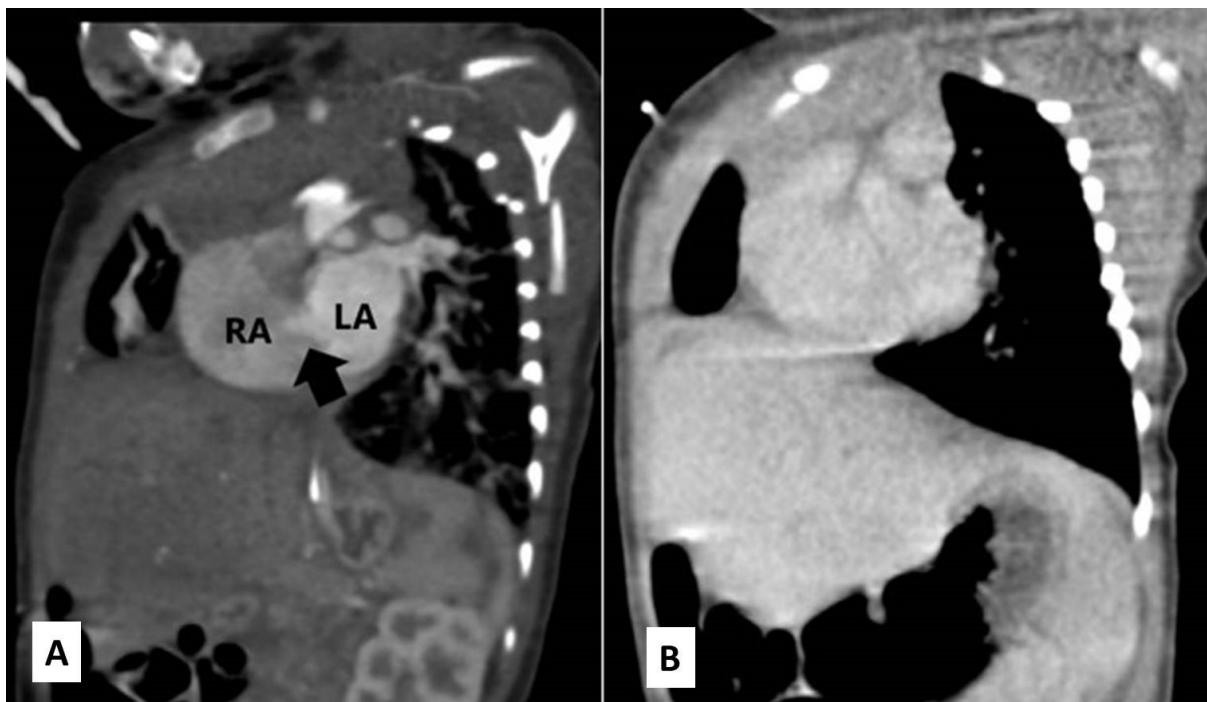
Sagittal reformatted image of CT thorax in arterial (A) and venous phase (B) showing the cardiac anomaly. Note that the interatrial septal defect is appreciated in arterial phase (black arrow) which cannot be appreciated in venous phase. Left atrium (LA) and right atrium (RA) are shown. (Click on image to enlarge)
